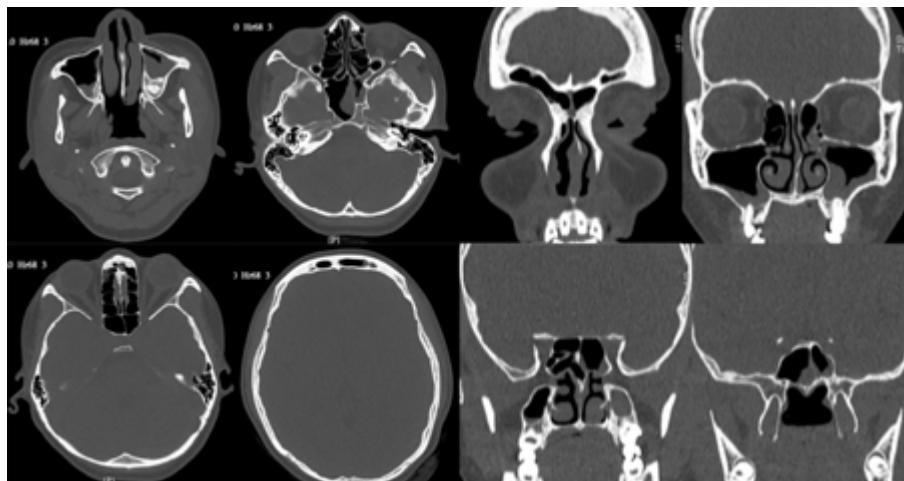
Non-contrast head CT scan showed mucosal thickening of the bilateral frontal, maxillary, ethmoidal, and sphenoidal sinuses, consistent with pansinusitis. The ostiomeatal complexes were open, accompanied by conchal hypertrophy and a leftward deviation of the nasal septum. Non-contrast head CT scan (axial, sagittal, and coronal views) of a 61-year-old male presenting with persistent hiccups.
